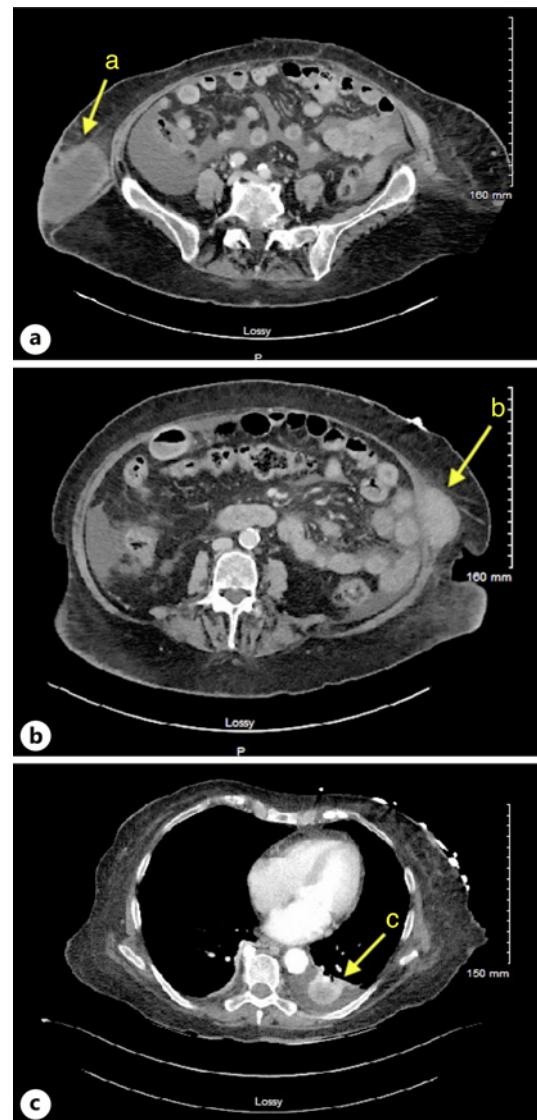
CT findings. a Right abdominal wall 6.3 × 5.5 × 5.5 cm peripherally enhancing mass with central low-attenuation. b Left abdominal wall 5.6 × 3.4 × 12.2 cm enhancing mass. c Left lower lobe 2 cm pulmonary nodule.
